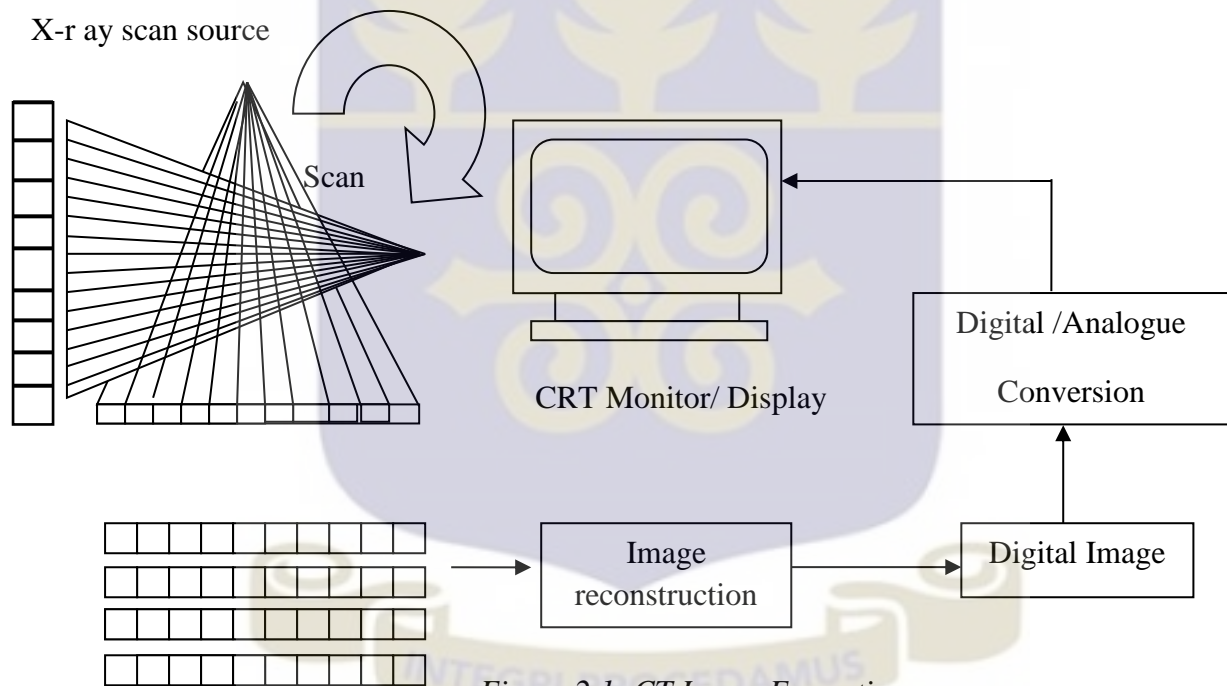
CT Image Formation.
